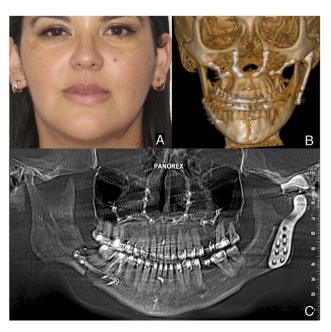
(A) Six-month follow-up showing stability in the facial midline and contouring symmetry. (B) Computed tomography showing internal rigid fixation with skeletal symmetry and the TMJ prosthesis with no complications. (C) Orthopantomography showing the position of the TMJ prosthesis and the osteotomy in the basilar border of the left mandibular angle and body. TMJ indicates temporomandibular joint.
